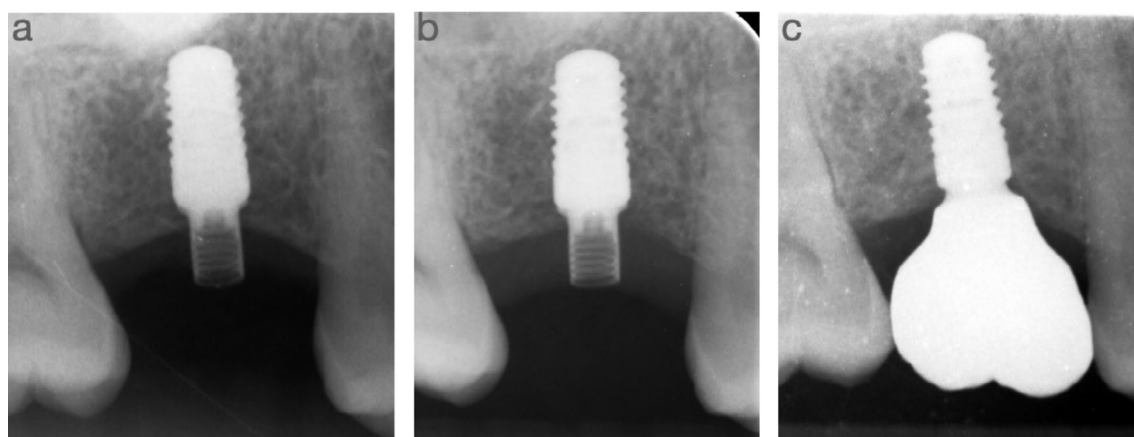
Standardized radiography procedure: (a) after surgery and placement of the experimental abutment, (b) at the 8 weeks control, and (c) at the 3 months control after crown placement.
